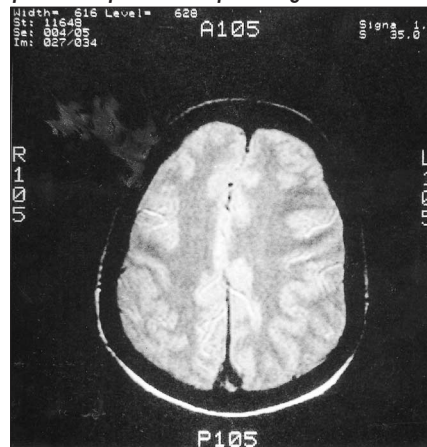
Enhanced T1-weighted axial image showing a filling defect at the confluence of the sinuses with associated midline shift.
